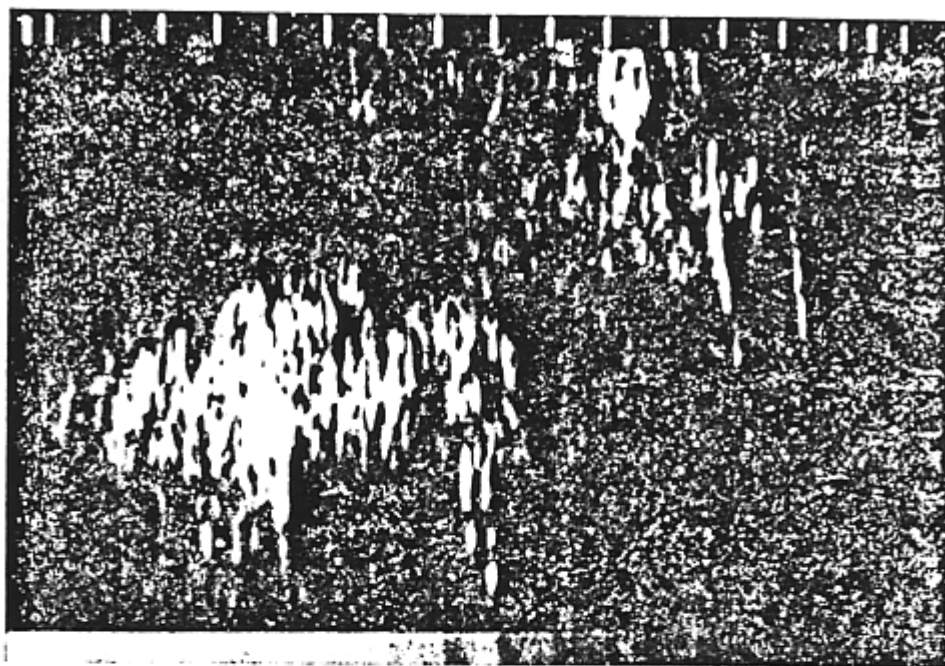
Sonographic picture of chorion frondosum biopsy using real time equipment; ch: chorion; gs: gestational sac; c: cannula.
